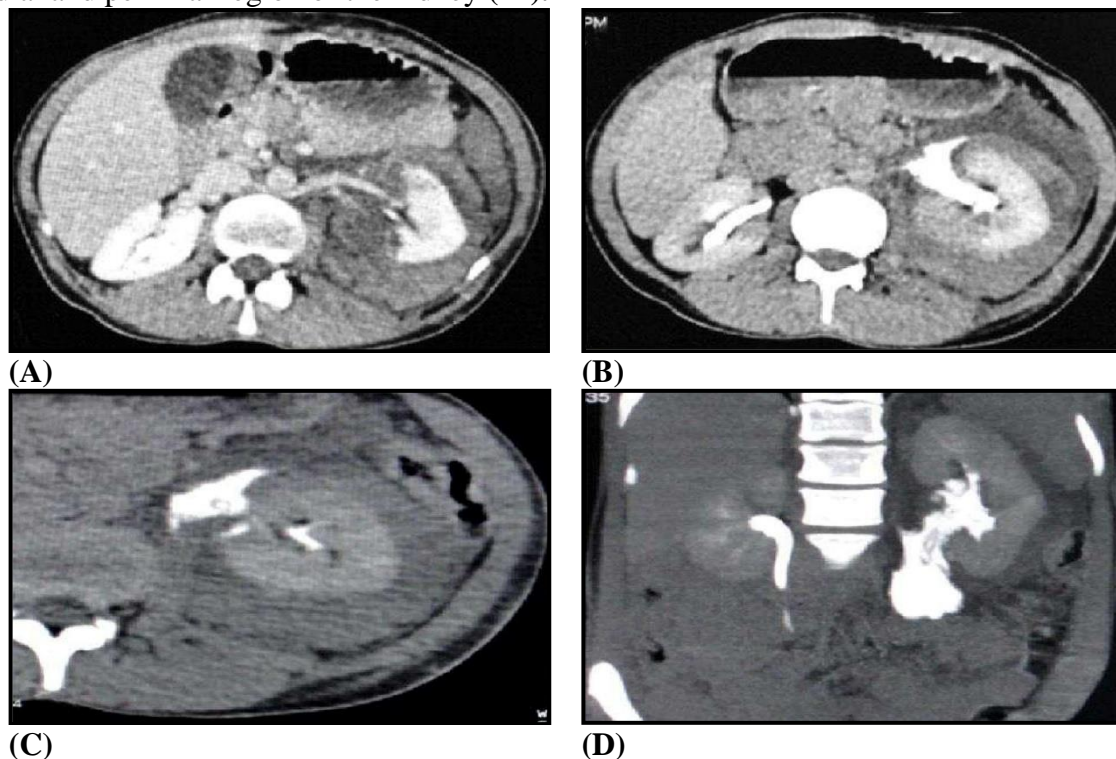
Grade IV injury (Laceration involving the pelvicalyceal system). Contrast enhanced computed tomography (CECT) images of a 7-year-old male who had a fall from height with resulting blunt trauma to the abdomen. A: Axial; B: Sagittal section showing deep laceration in lower pole of the right kidney extending up to the renal hilum; C: Sagittal section; D: Thick coronal maximum intensity projection image of the excretory phase shows leakage of excreted opacified urine (arrow) through the laceration suggesting PCS injury with resultant urinoma (a) formation around lower pole of right kidney (13)
